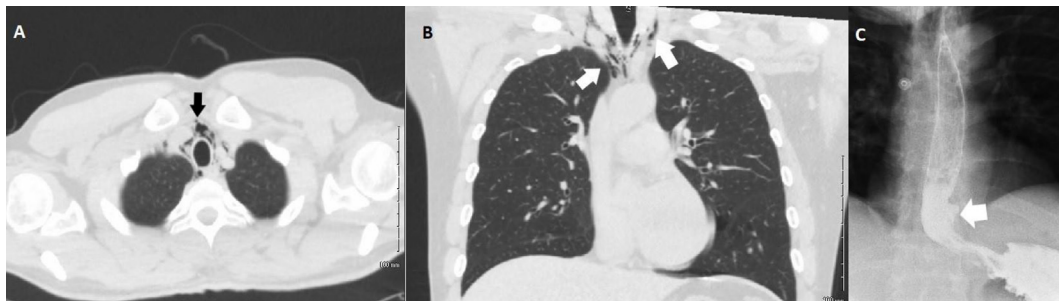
Radiological images confirming esophageal perforation. A & B depict the pneumomediastinum in the soft tissues of the neck on CT (Arrows). C depicts the esophagram with contrast extravasation from the distal esophagus (White Arrow).
